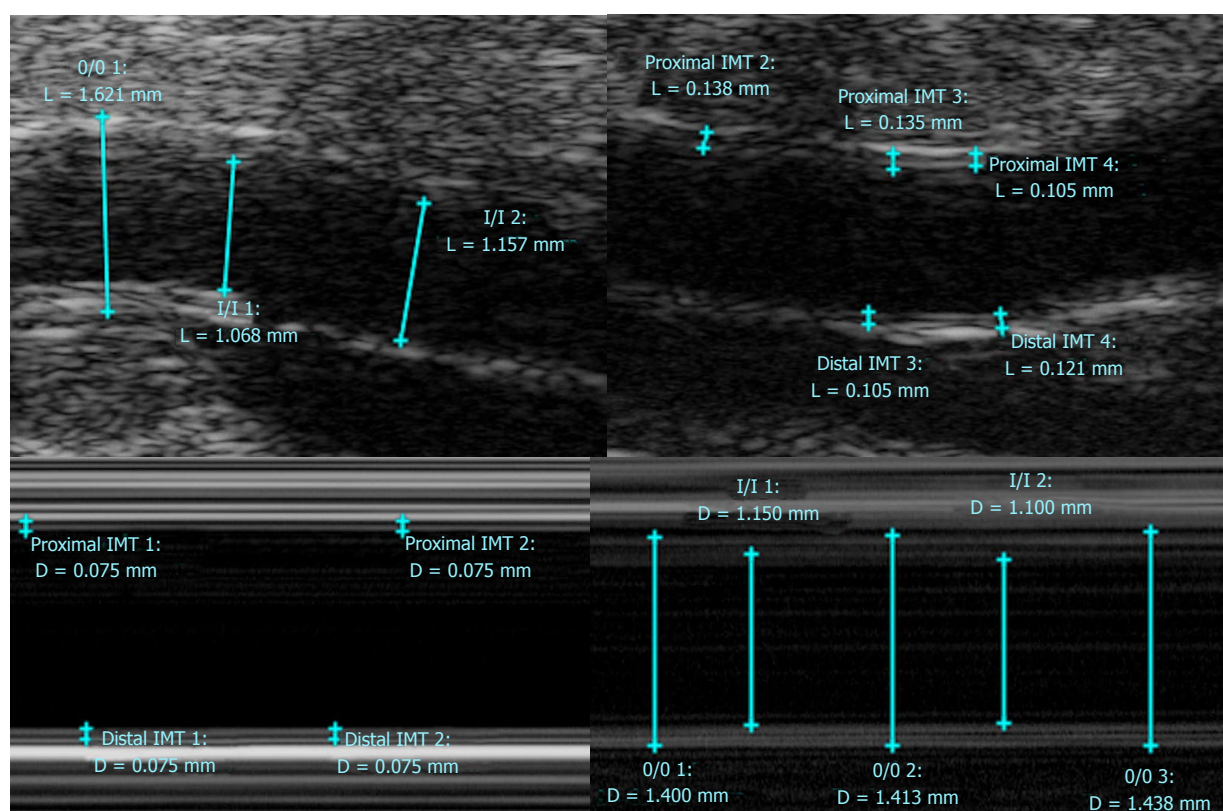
Ultrasound Images (B mode, M mode).
